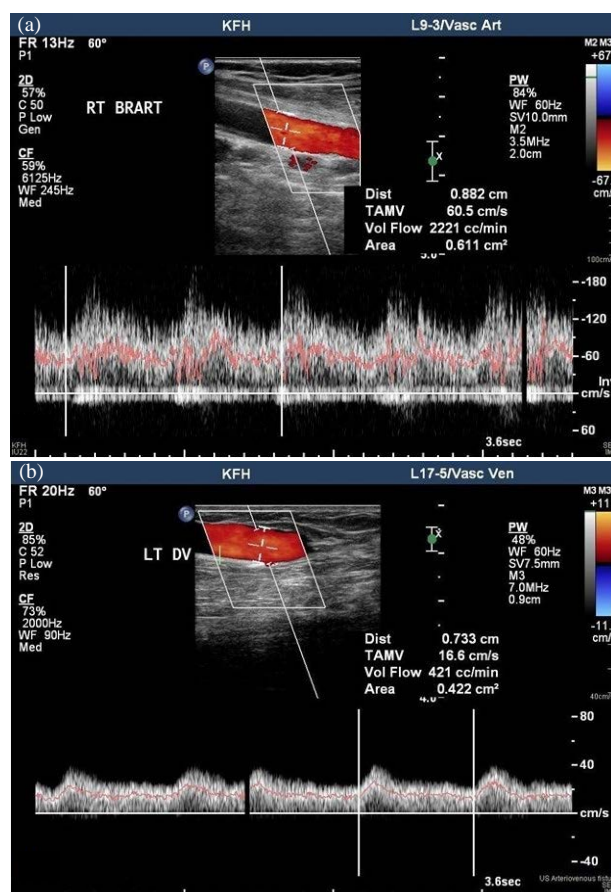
(a-b): Duplex ultrasound images of different two patients with arteriovenous fistula for hemodialysis shows (a) high blood flow volume (2221 mL min^{-1}) in the right brachial artery and (b) low blood flow volume (421 mL min^{-1})
